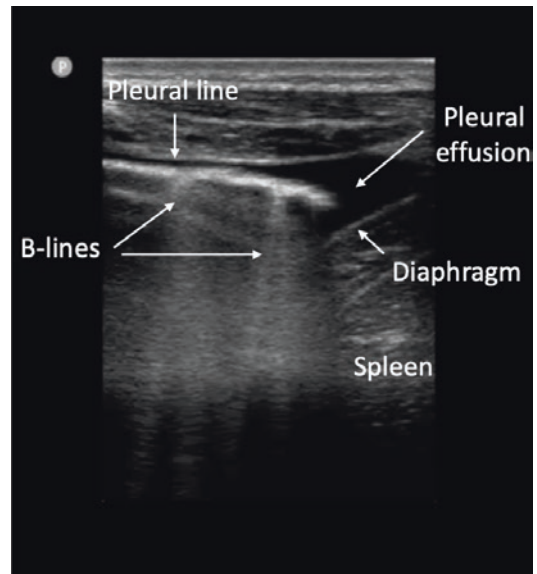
Linear probe 2D ultrasound image at the costophrenic angle demonstrates a few scattered B-lines in the left lower lung and a small, simple hypoechoic pleural effusion
